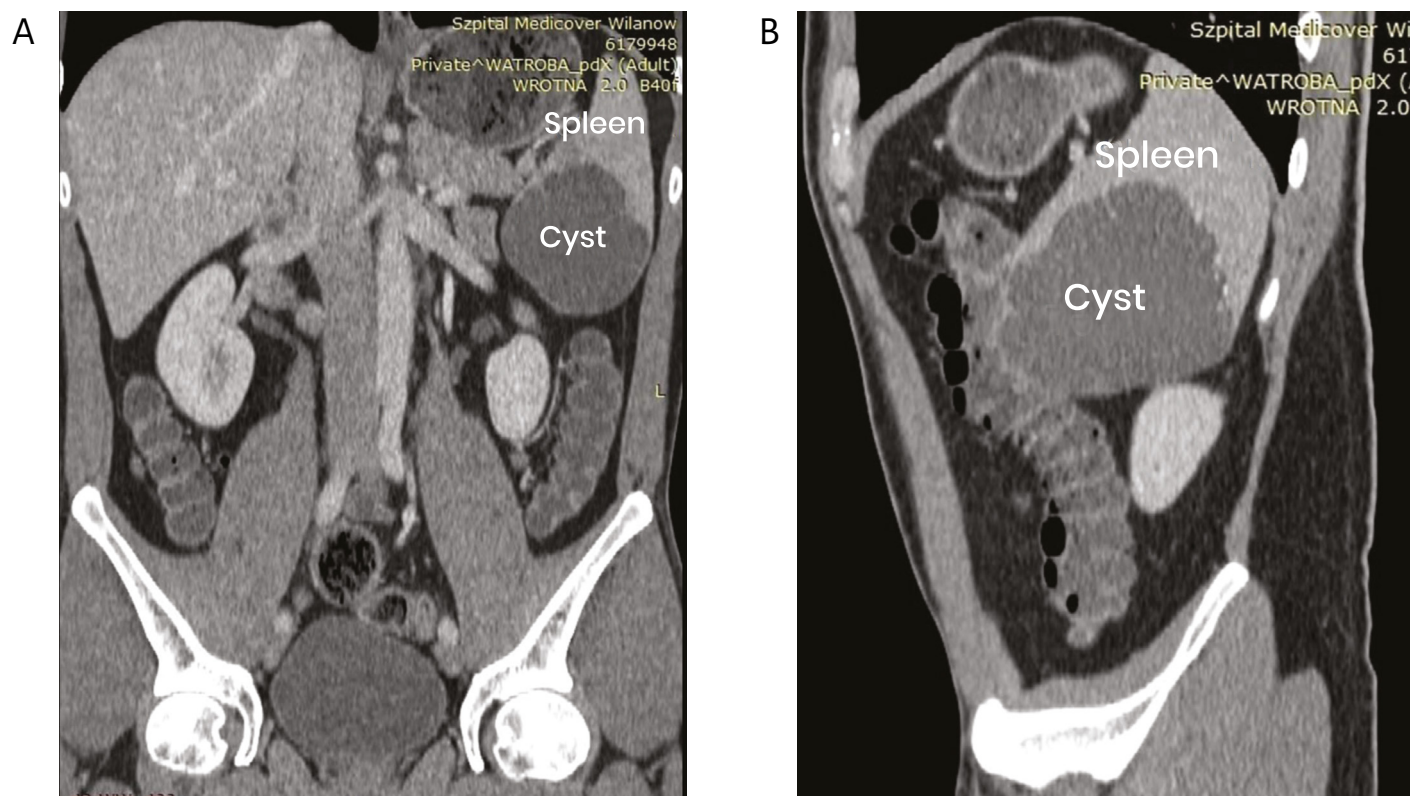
(A) Case no. 3. Abdominal CT with view of giant splenic cyst (p-a view); (B) Case no. 3. Abdominal CT with visible giant splenic cyst (lateral view).
